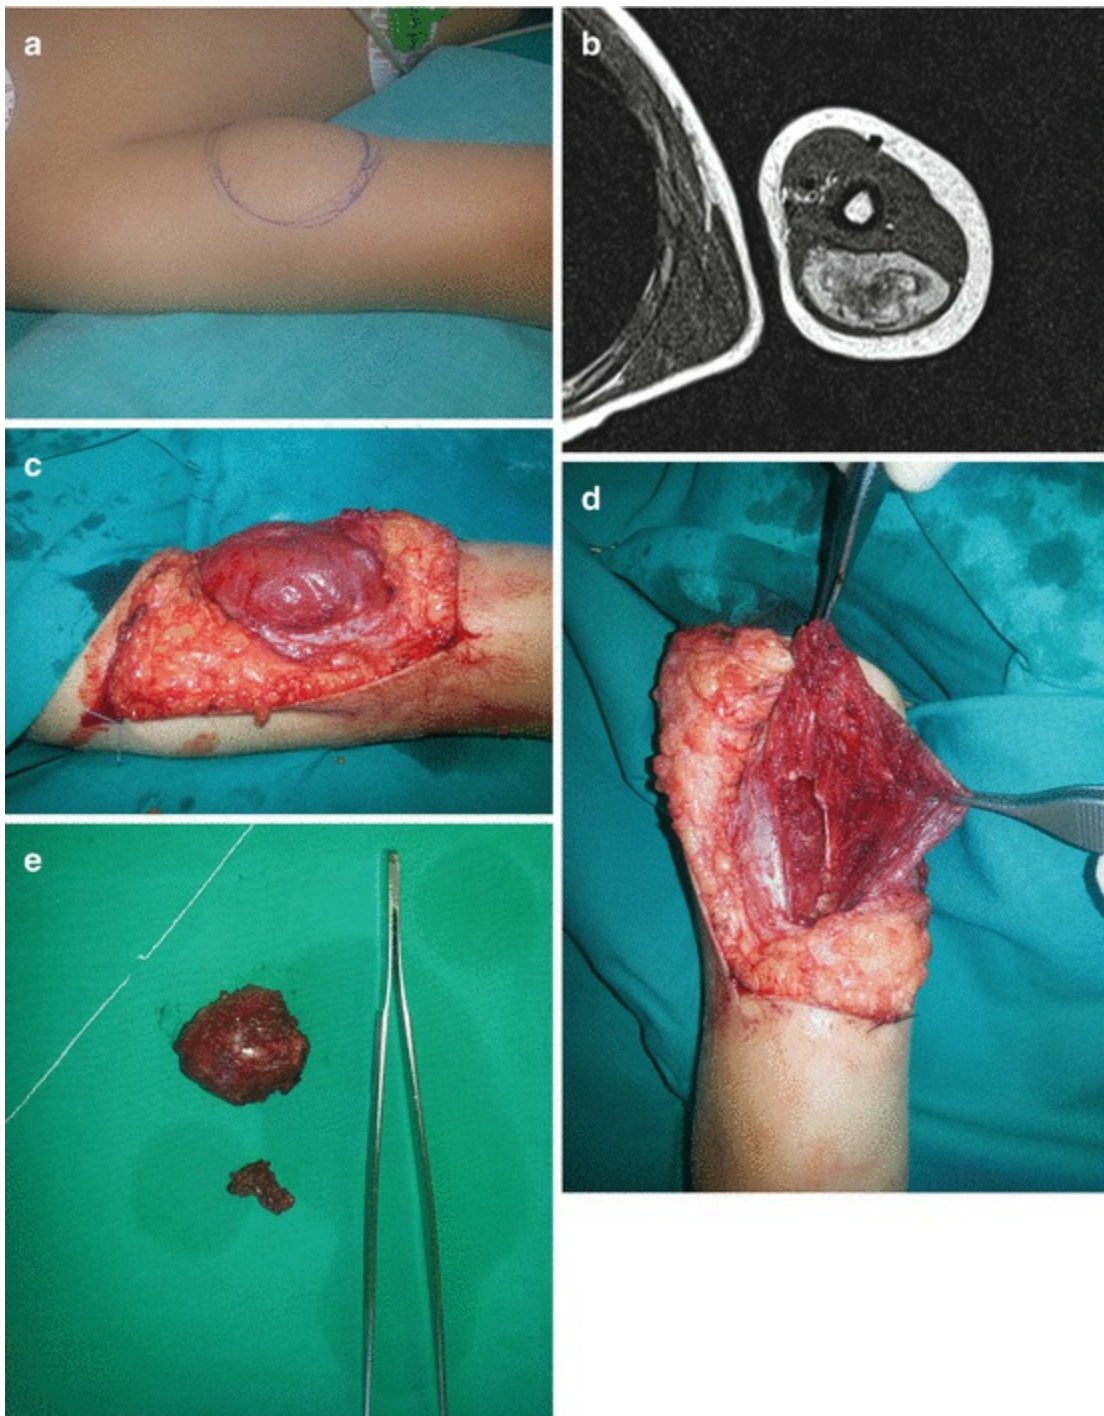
Surgical treatment of deep localized venous malformation: (a) preoperative view; (b) magnetic resonance imaging of the left brachial region; (c, d) intraoperative view; (e) complete excision of venous malformation
